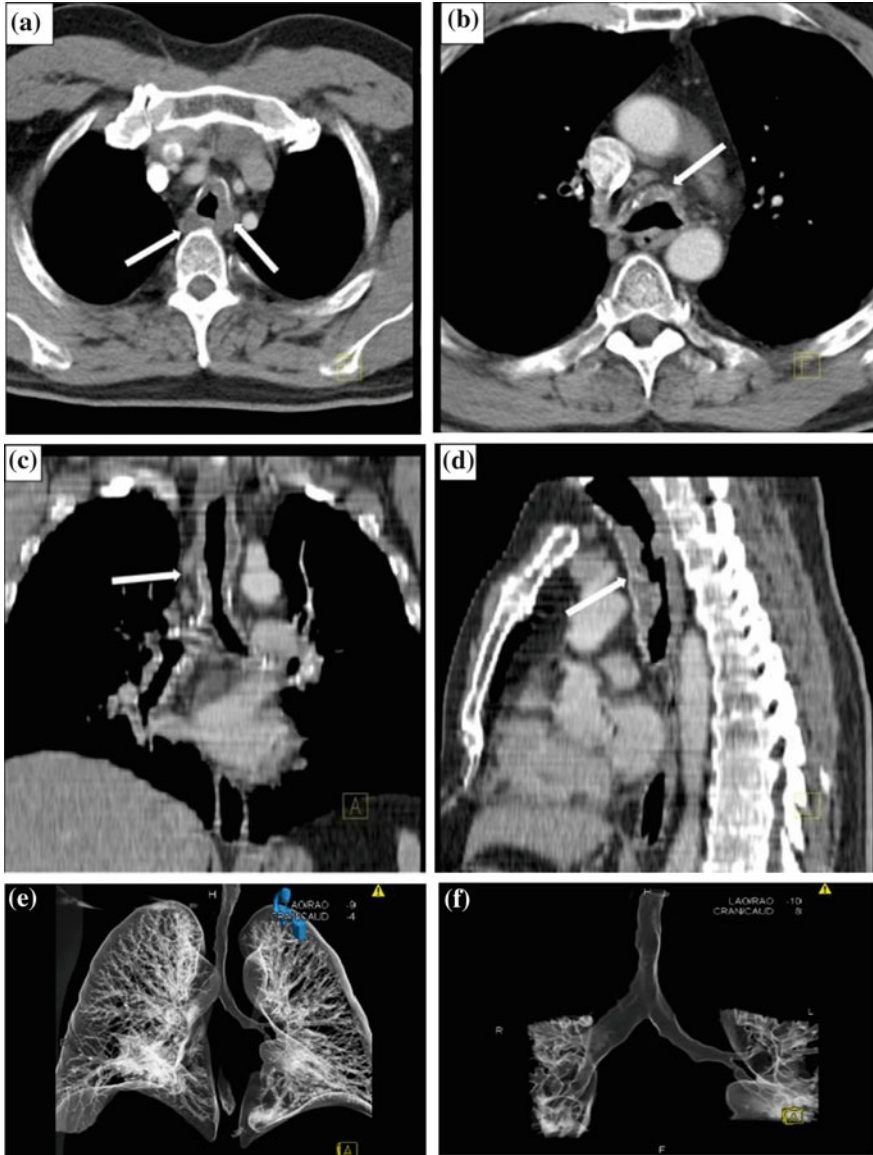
a Axial CT image of the trachea demonstrating eccentric nodular masses along the posterolateral wall (*closed white arrow*). b Axial image from the same patient at the level of the carina and main-stem bronchi demonstrating diffuse circumferential wall thickening with foci of calcifications and luminal narrowing (*closed white arrow*). c, d Sagittal and coronal contrast-enhanced CT showing diffuse circumferential thickening of the tracheobronchial airway. e, f 3D external rendering showing airway narrowing, irregular tracheobronchial mucosa. Note right middle lobe subsegmental collapse. Distal airways are patent
